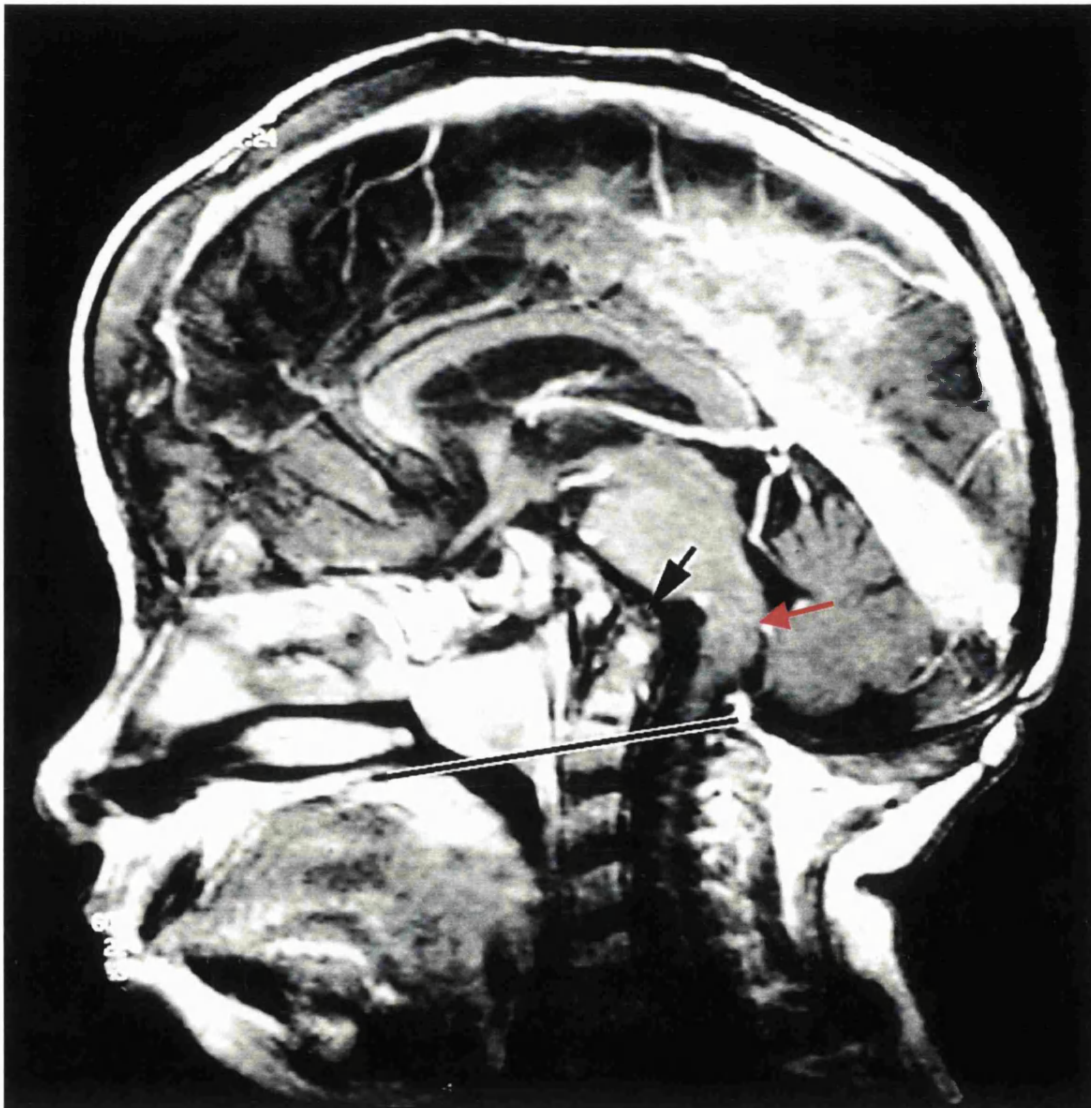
Midline sagittal MRI showing gross basilar invagination
